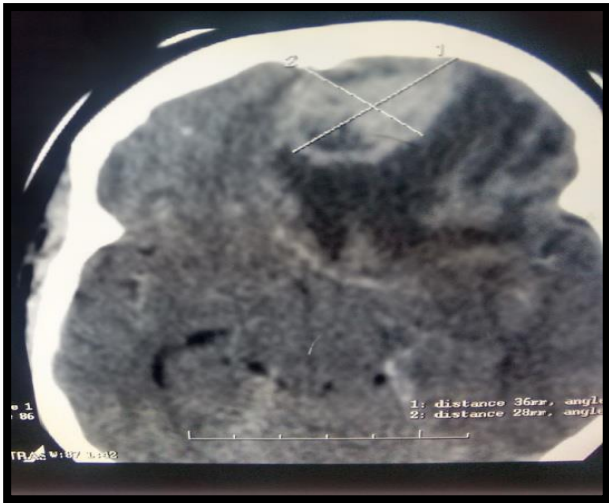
Contrast enhanced CT scan showing a sphenoid wing Meningioma with PTBE.
